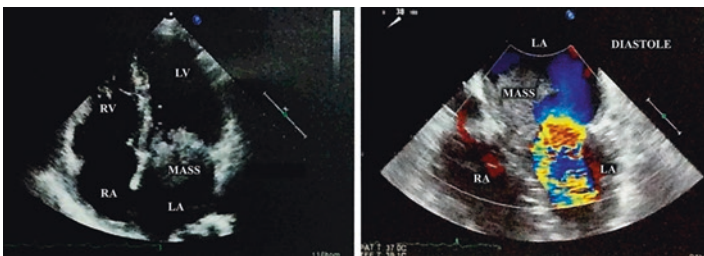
Transesophageal echocardiographic examination
